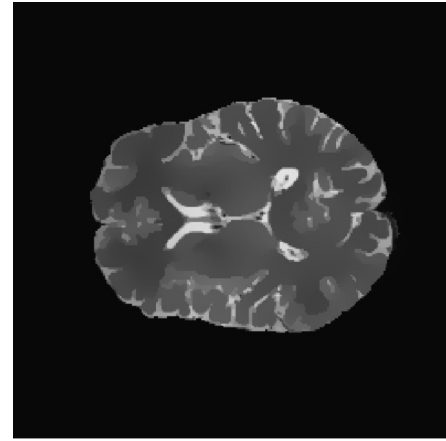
Anisotropic filtering results of the axial MRI image shown in Fig. 2, after 150 iterations.
